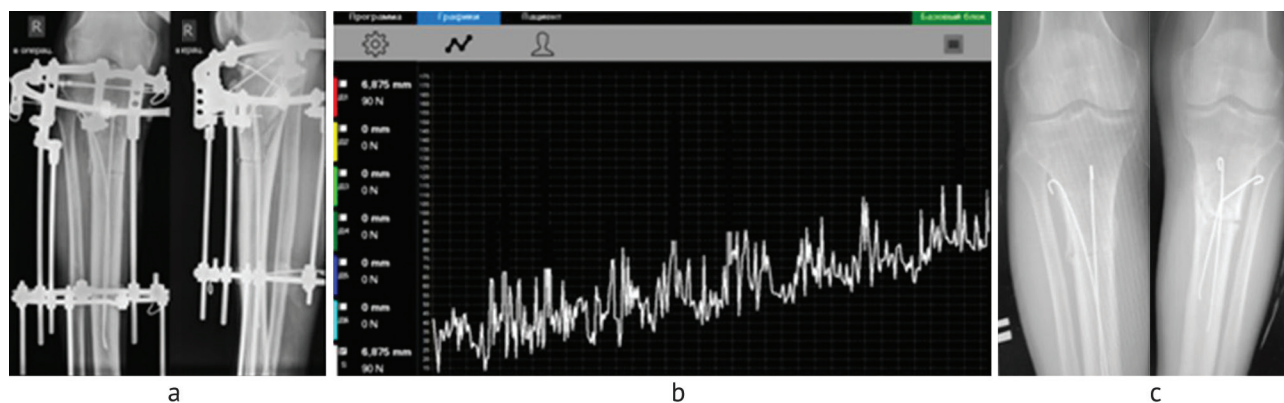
Radiographs of the right tibia on the day of surgery (a), dynamics of distraction forces during correction of genu varum on the right side (b), radiographs of both tibiae after the treatment completed (c)
